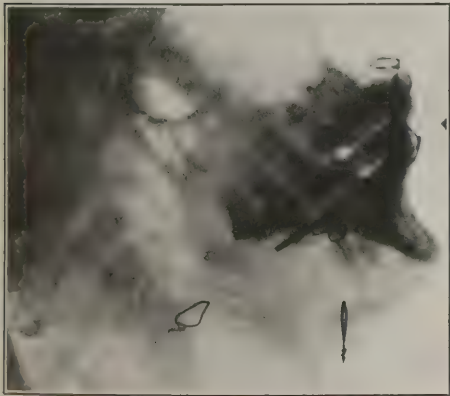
Case 11: Radiograph showing graft in place, shortly after operation.
